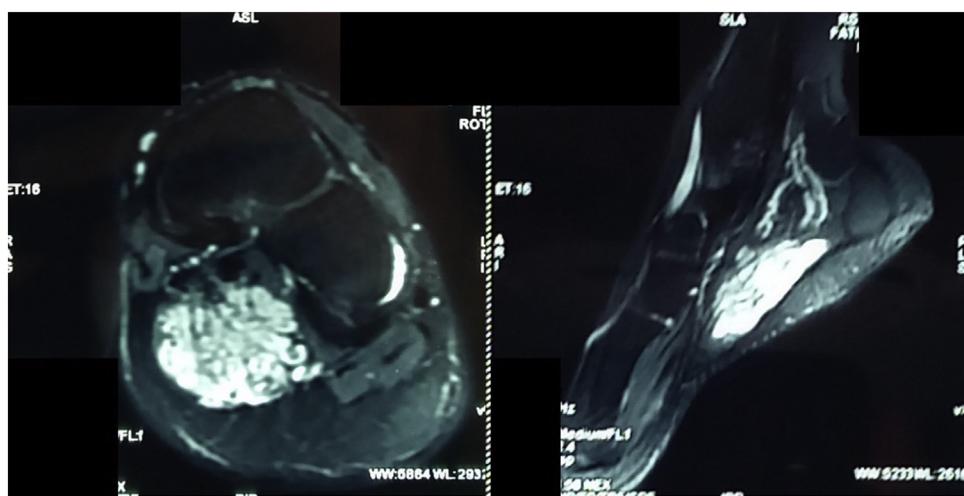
Coronal and sagittal view of the patient's left foot MRI showed a heterogenous multilobulated mass.
